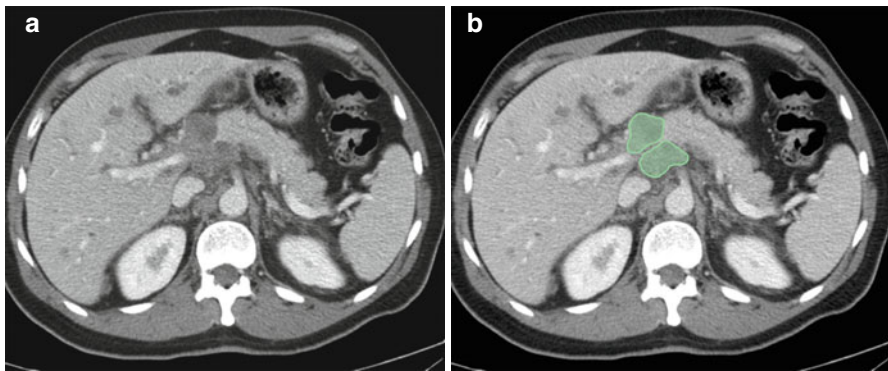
(a, b) Axial CT image in a patient with hepatoma shows enlarged nodes in the periportal (*green*) and peripancreatic location causing secondary biliary obstruction
